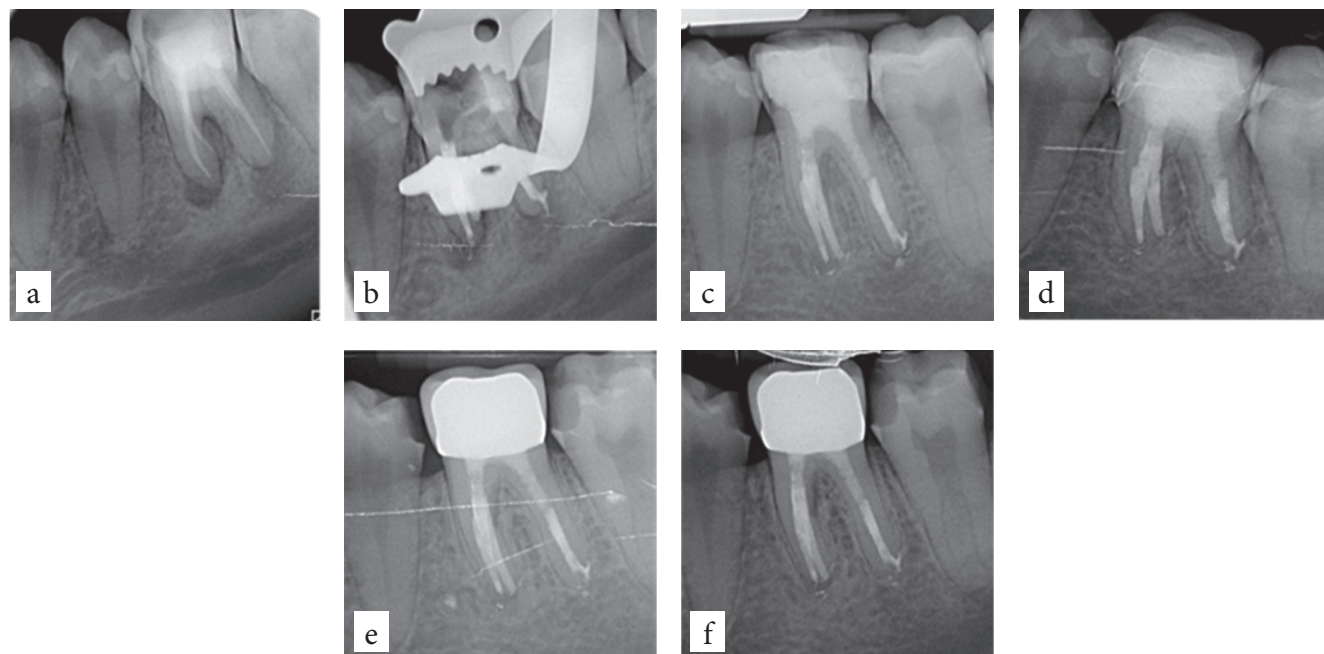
Example of retreatment of a mandibular molar with severe periodontitis (PAI 5). At 1 and 2 years recalls, PAI score dramatically decreased, there are still some bone changes with mineral loss, but at 4 years recall the tooth is healed. The 6 years recall confirms the healing, but the overfilling with sealer is still there; a – preoperative radiograph, PAI 5; b – postoperative radiograph; c – follow-up at 1 year, uncertain; d – follow-up at 2 yrs, uncertain; e – follow-up at 4 yrs, health; f – follow-up at 6 yrs, health.
